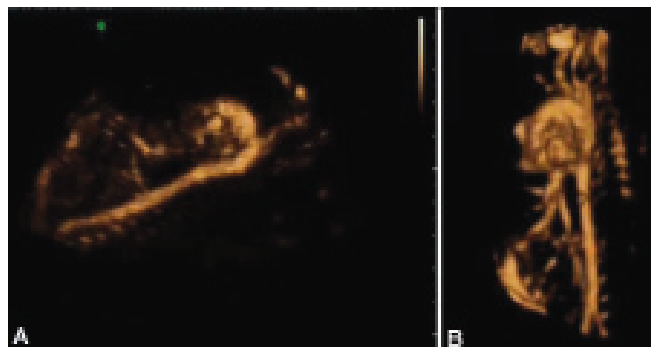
to D: Three-dimensional images of the fetal heart showing the variety of flow mapping modalities. (A) Spatial and temporal image correlation (STIC) color Doppler; (B) STIC HD flow (bidirectional Power Doppler) displayed in transparent glass body rendering mode; (C) STIC Power Doppler displayed in transparent glass body rendering mode; (D) STIC B-flow
